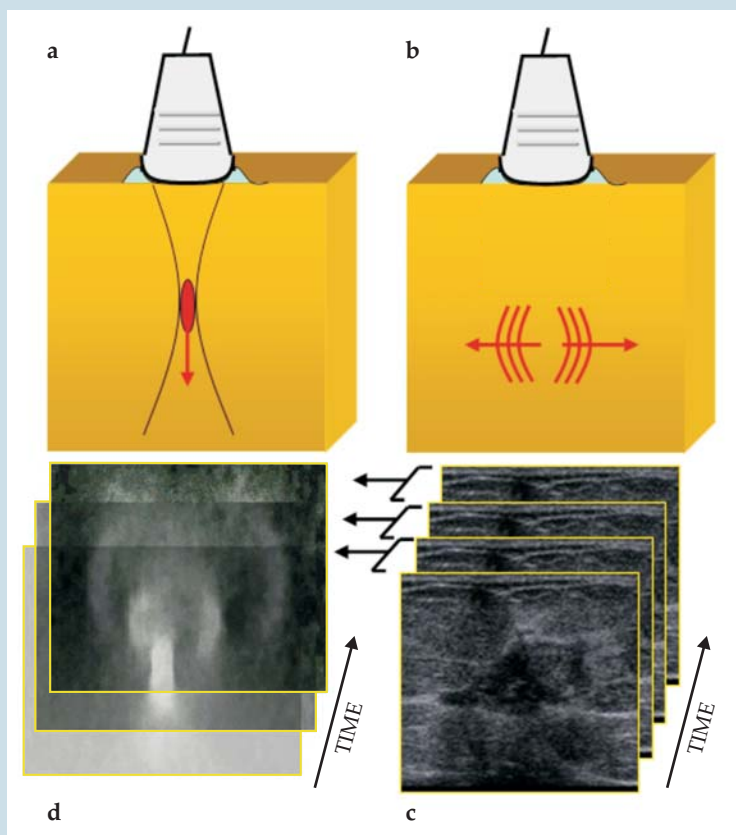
Elasticity imaging. (a) An ultrasonic probe generates a force in the focal area that pushes in the direction of beam propagation. (b) Relaxation of the pushed tissue generates a low-frequency shear wave. The ultrasonic array then switches into an ultrafast imaging mode. (c) Ultrasonic images, dominated by speckle patterns, are created and then stored into memories. (d) Correlation of the speckle patterns in sequential frames yields an image of the tissue displacement induced by the shear wave.
